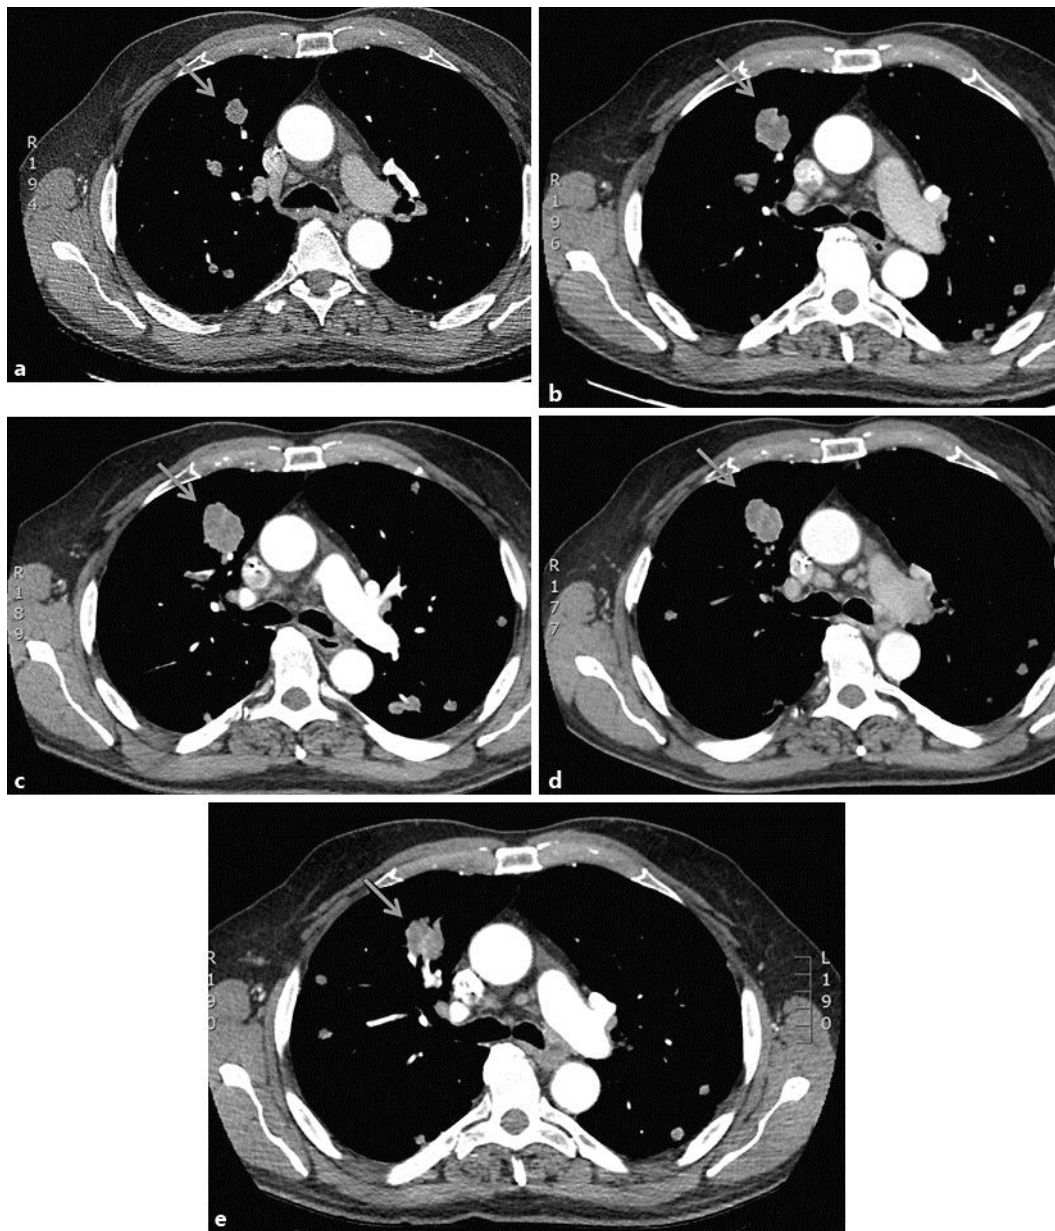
CT images from case 2. Day numbers refer to the days after the first RRx-001 dose. The arrows indicate the target lesion whose change in longest diameter is shown in Figure 3. a Chest CT scan, measured at day 50 and showing stable disease. b Chest CT scan on day 186, showing an increased size of the mass in the right lung field. Dosing with RRx-001 was stopped. c Chest CT on day 228, 42 days after RRx-001 was stopped, showing a significant enlargement of the right upper lobe mass and interval nodule growth. The patient was not treated during this period. d Chest CT scan on day 256, approximately 4 weeks after treatment with FOLFIRI, was commenced, showing a modest reduction in the size of the right upper lobe mass and pulmonary lesions. e Chest CT scan on day 294, approximately 8 weeks after treatment with FOLFIRI was started, showing further tumor shrinkage.
